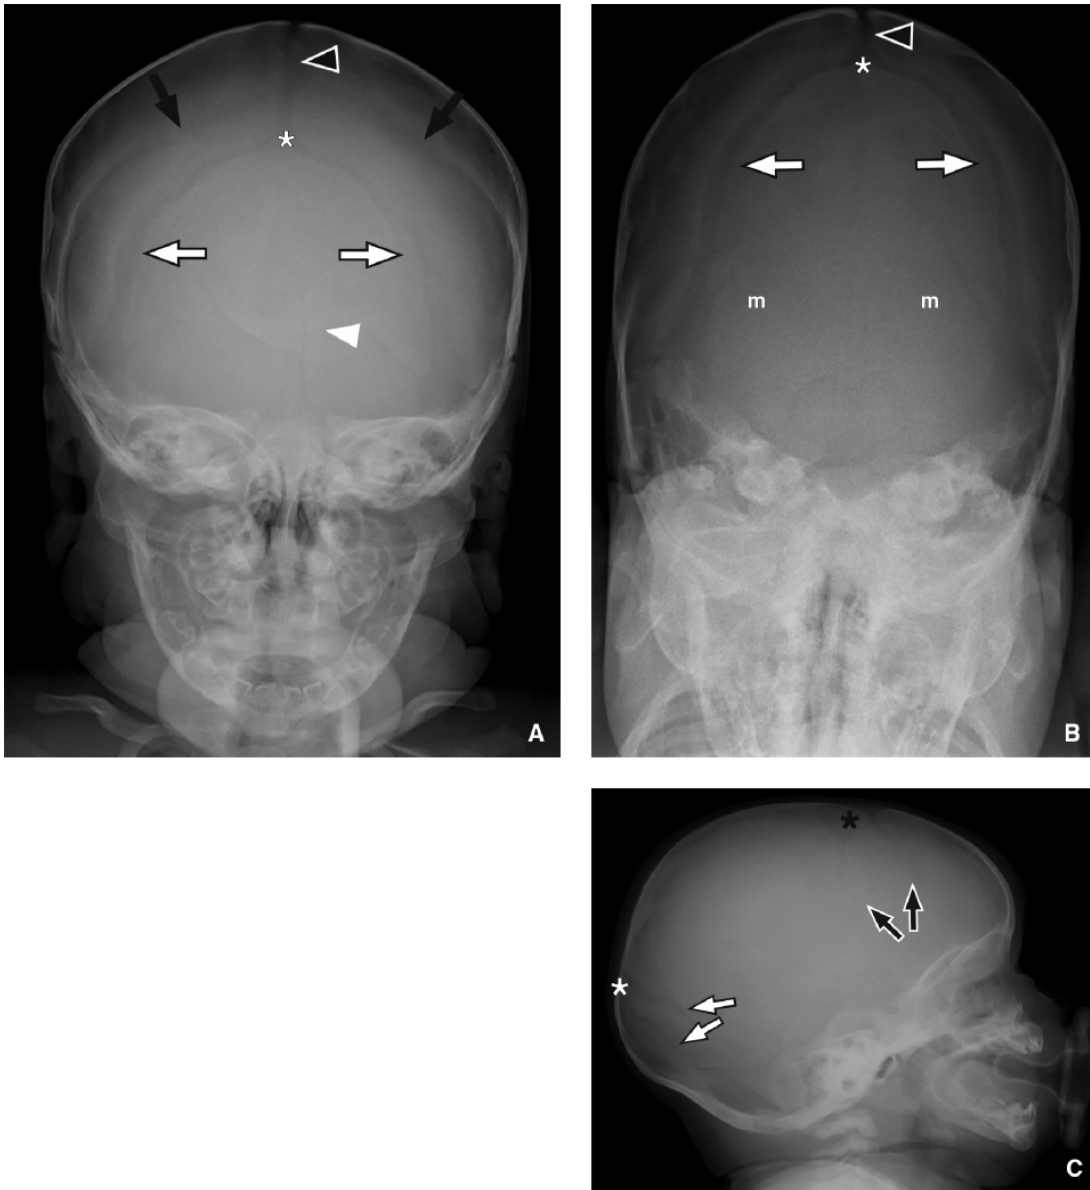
Skull radiographs of a normal 3-month-old boy: posteroanterior (PA) (A), Townes (B), and lateral (C) projections. *Black arrows* indicate coronal sutures, *black arrowhead* the sagittal suture, *white arrows* the lambdoid sutures, *white arrowhead* the metopic suture, *white asterisk* the posterior fontanelle, *black asterisk* the anterior fontanelle, and “*m*” the mendosal sutures.
